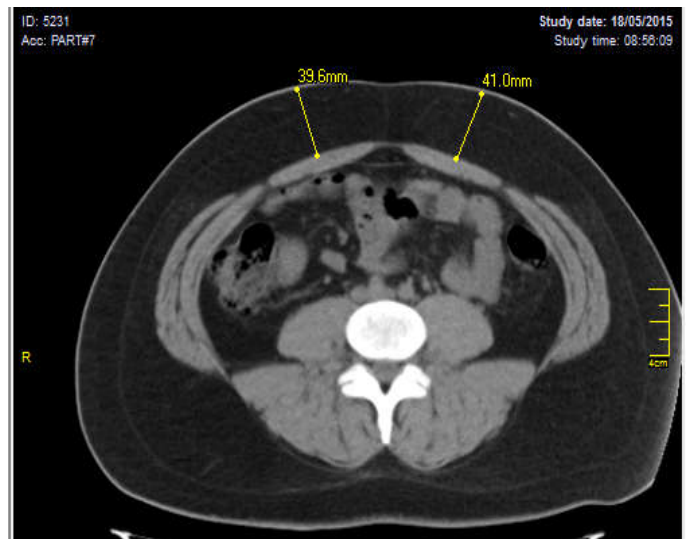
Patient caliper measurement was 5.4 cm, related to 39.6 and 41 mm CT scan measurements
